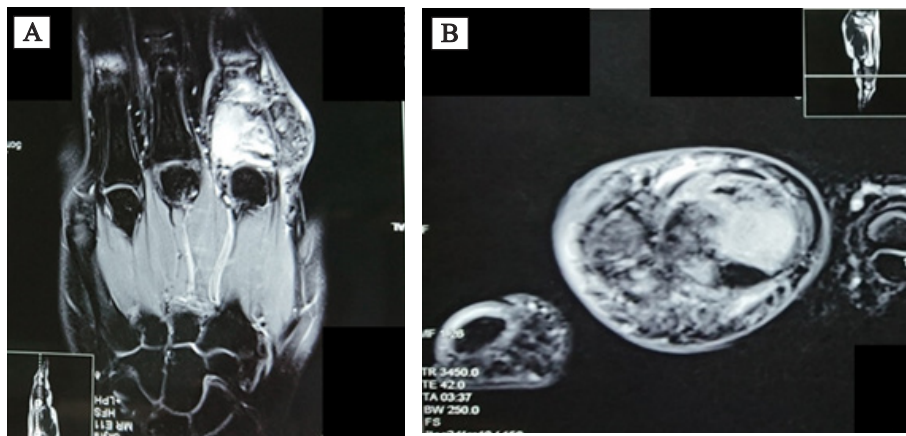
(A) Coronal and (B) Axial view of the MRI showed an expansive mass of the proximal phalanx resembling an aggressive nature of the GCT of the hand bones.
